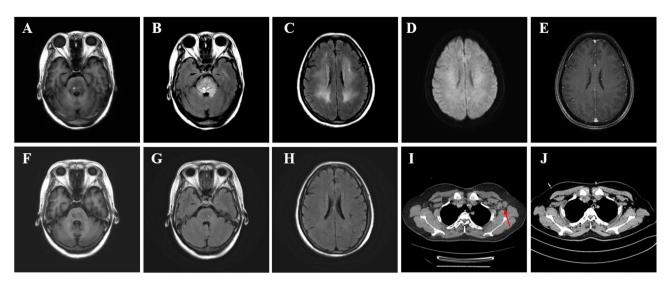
(A-E) Initial MRI of the brain shows the lesion in the pontine region and bilateral periventricular areas. Imaging on T1WI (A), T2-FLAIR (B-C), DWI (D), and contrast (E) is shown, respectively. (I) Initial CT of the chest reveals lymphadenopathy in the left axillary region (red arrow). (F-H, J) Follow up imaging after treatment reveals nearly complete resolution of all the lesions
